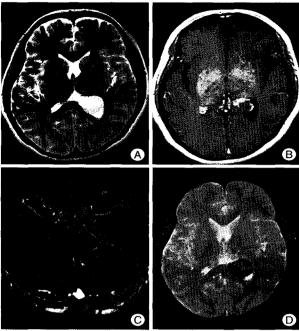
Preoperative Brain magnetic resonance (MR) image and computed tomography (CT) head angiography. A: T2-weighted image showing a mass at the left trigonal region without hydrocephalus or edema. B: Preoperative gadolinum-enhanced T1-weighted MR image demonstrating a scanty enhanced lesion. C: Preoperative CT-head angiography revealing no definite feeding arteries. D: preoperative gradient echo MR image showing intratumoral hemorrhage or thrombosis
